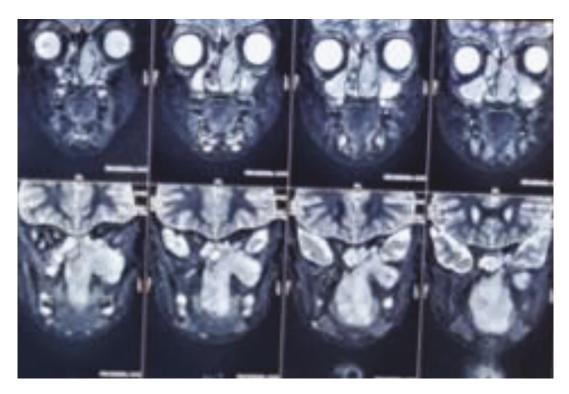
MRI scan shows a hyperintense lesion present in the left maxillary sinus
